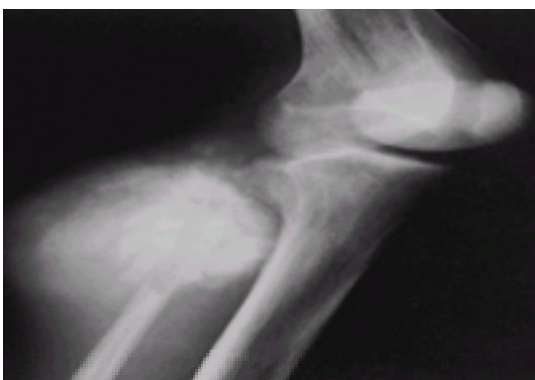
Osteosarcoma in the fibula in a 14-year-old girl. Radiograph shows lytic bone destruction, malignant new bone formation, cortical breakthrough, and massive extraosseous tumor.
